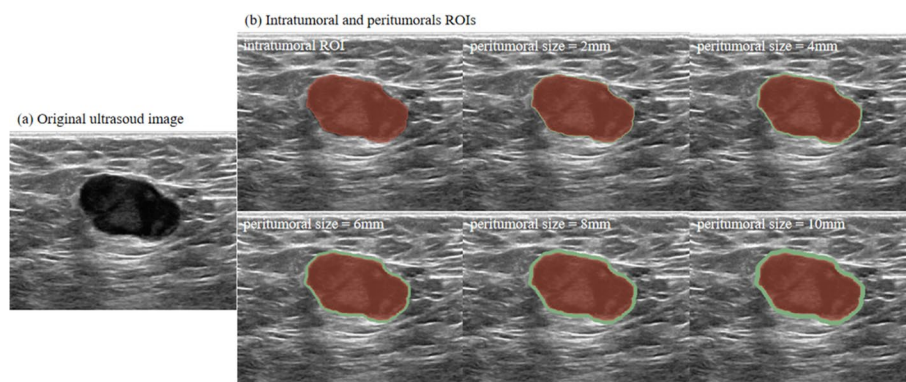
Representative ultrasound images and their corresponding intratumoral and peritumoral ROIs. a Original ultrasound image. b Intratumoral ROI (red regions) and different ranges of peritumoral ROIs (green regions)
